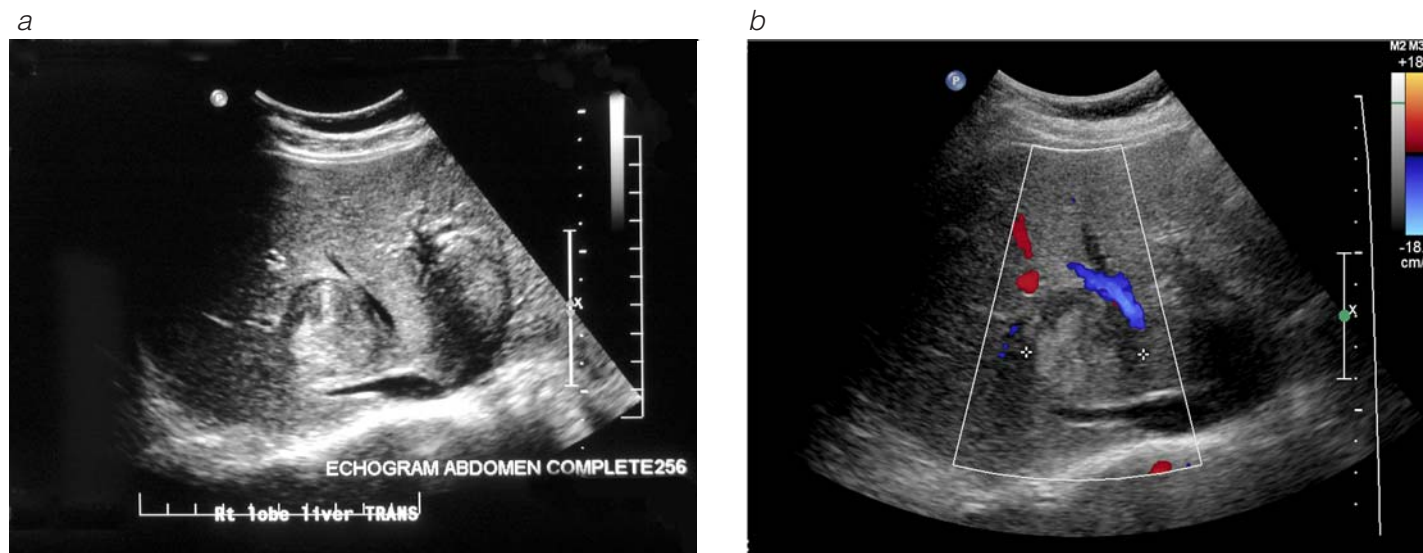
(a) Transverse ultrasonogram of the liver of a 72-year-old cirrhotic patient with a hepatitis C infection shows a 4.0 × 3.5 cm hepatoma, nestled between the right and middle hepatic veins and closely apposed to the inferior vena cava. (b) Color Doppler ultrasonogram from the same patient displays blood flow in the middle hepatic vein and the surrounding liver parenchyma. Blood flow toward the transducer is usually displayed in shades of red, whereas blood flow away from the transducer is displayed in shades of blue. Color Doppler ultrasonography allows evaluation of the patency and flow characteristics of the hepatic circulation as it relates to the mass.
